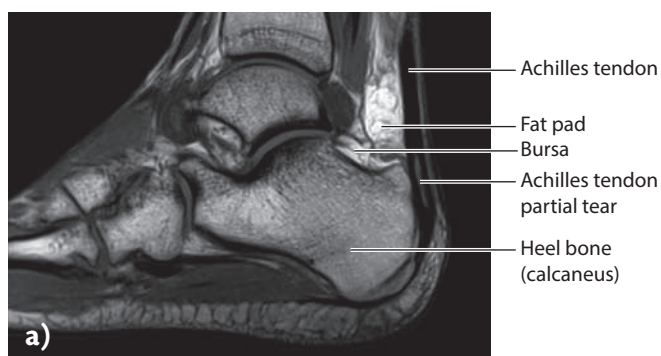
Diagnosis of a tendon injury can be made in several ways. a) Magnetic resonance imaging of an Achilles tendon is usually a very safe examination securing a correct diagnosis; the arrow shows a partial Achilles tendon injury; b, c) Ultrasound of the carpi radialis brevis tendon that inserts on the lateral epicondyle of the elbow. Injuries in ‘tennis elbow’ are located at this site and involves mostly this tendon.
